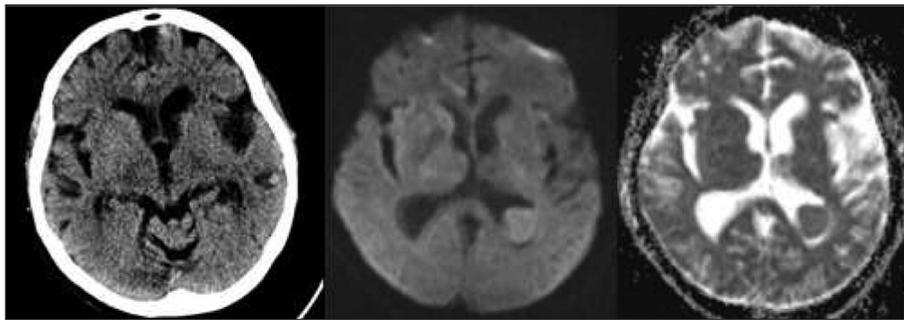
No acute changes were seen in computed tomography, diffusion weighted magnetic resonance imaging and apparent diffusion coefficient images.
